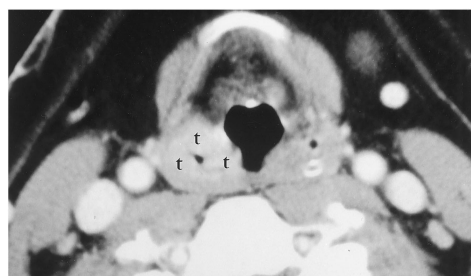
Squamous cell carcinoma of the piriform sinus. Axial enhanced CT image shows tumor (*t*) thickening the walls of the right piriform sinus.
